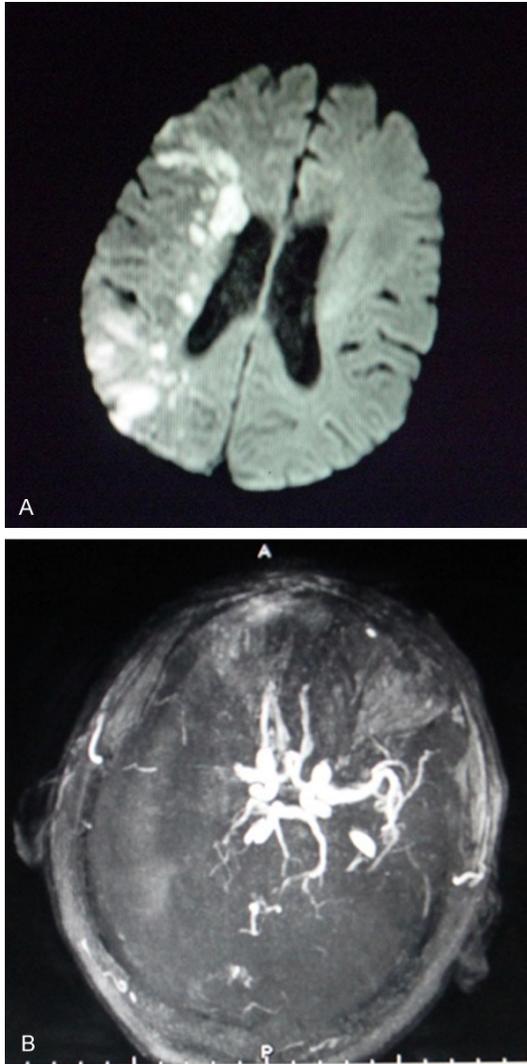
MRI performed at Jan 12th, 2015. A. DWI showed infarction on the field of right middle cerebral artery. B. MRA showed multiple cerebral artery stenosis and right MCA and internal carotid artery (ICA) disappeared.
